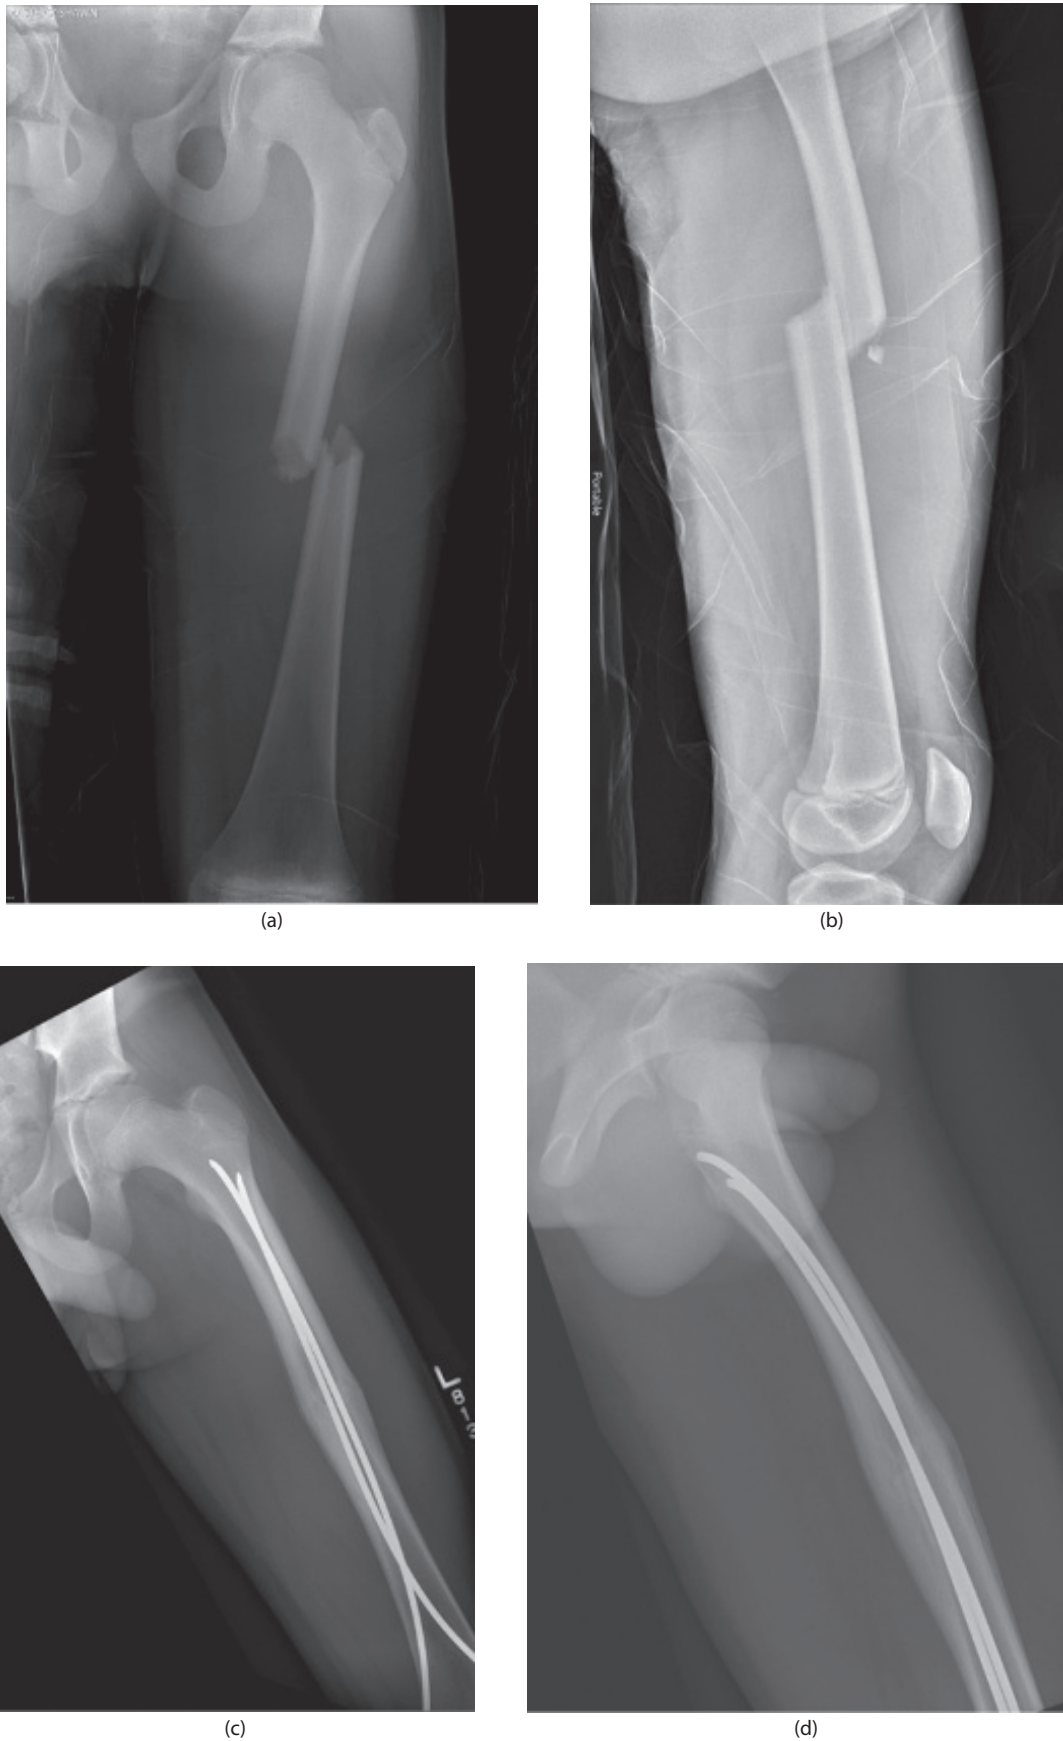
(a) and (b) Radiographs of an 11-year-old male who sustained a femoral shaft fracture on a trampoline. (c) and (d) Radiographs showing healing of his femoral shaft fracture at 6 months after treatment with flexible nails.
